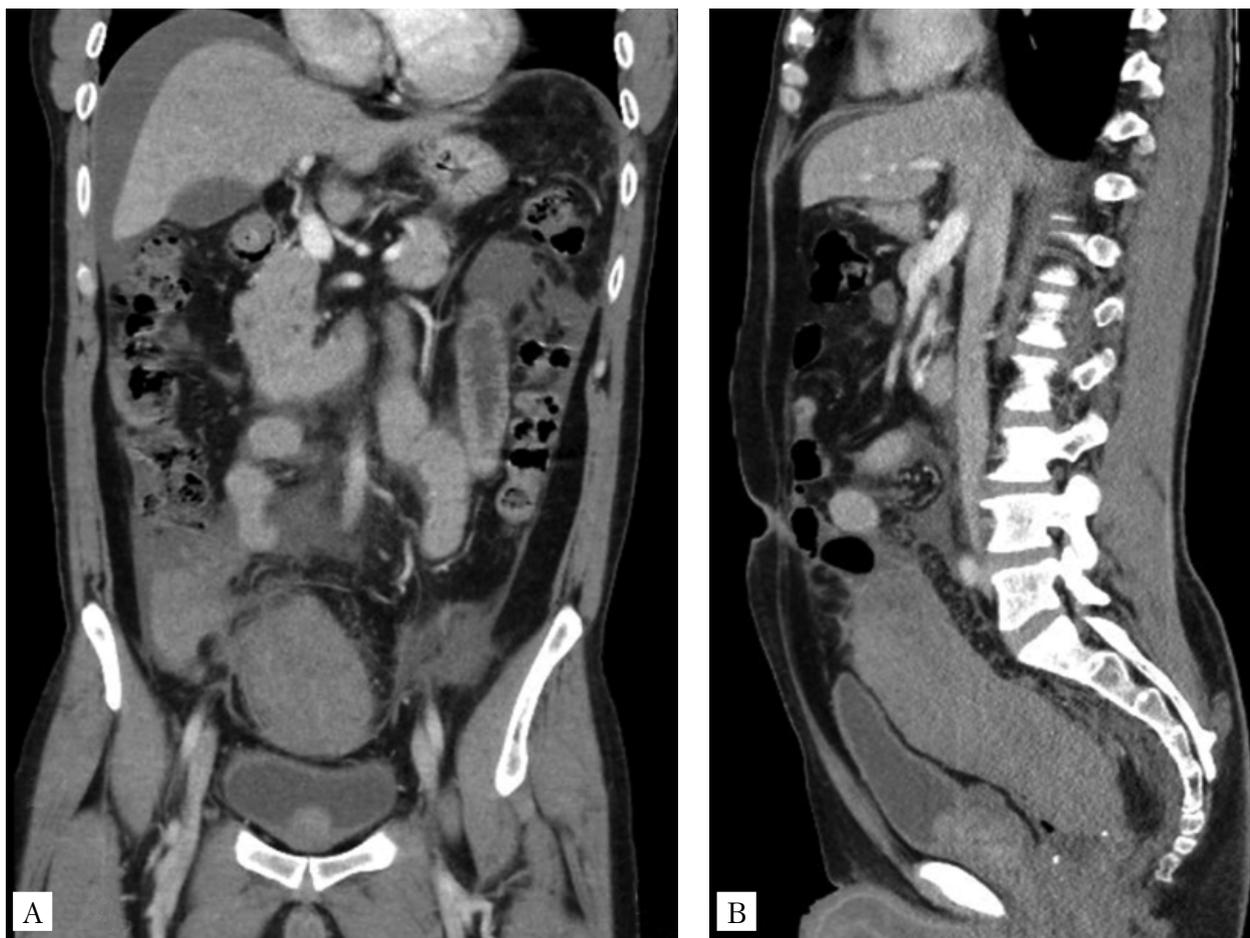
Postoperative imaging: computed tomography scan of the abdomen revealed a significant amount of free fluid in the abdomen (A); distension of the rectosigmoid junction (B)
